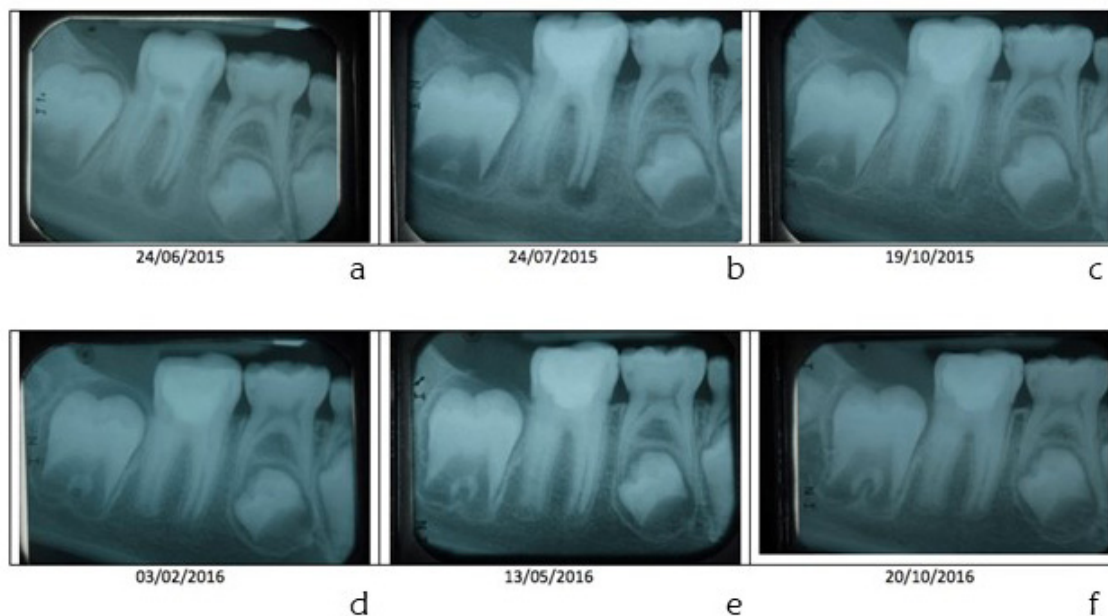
Radiographic examination at T0 (a) and reviewed at months 1 (b); 4 (c); 8 (d); 12 (e); 16 (f).
